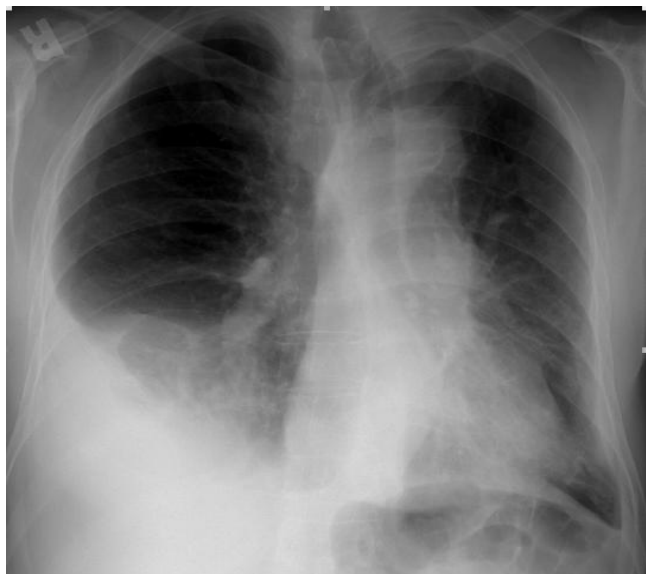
The x-ray showing a right-sided pleural effusion.
